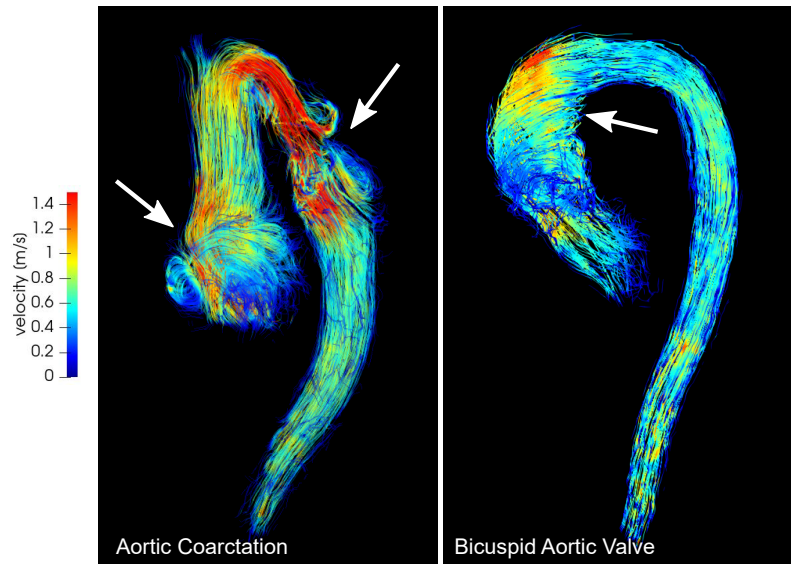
4D flow MRI streamline visualization in congenital defects of the aorta: (left) coarctation of DAo with increased flow velocity through stenotic region, and dilated aortic root with strong flow vortices at cusps; (right) bicuspid aortic valve that mediates helical flow in AAo.
